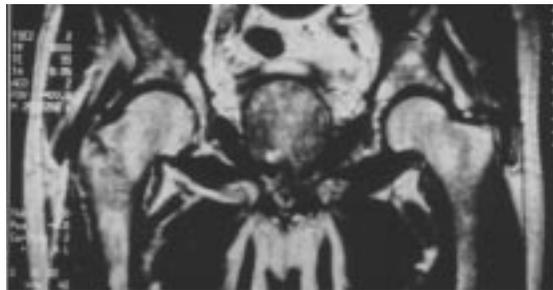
Magnetic resonance imaging study of a minimally displaced fracture of the right hip taken within 24 hours of injury. The fracture was not apparent on plain radiographs.
